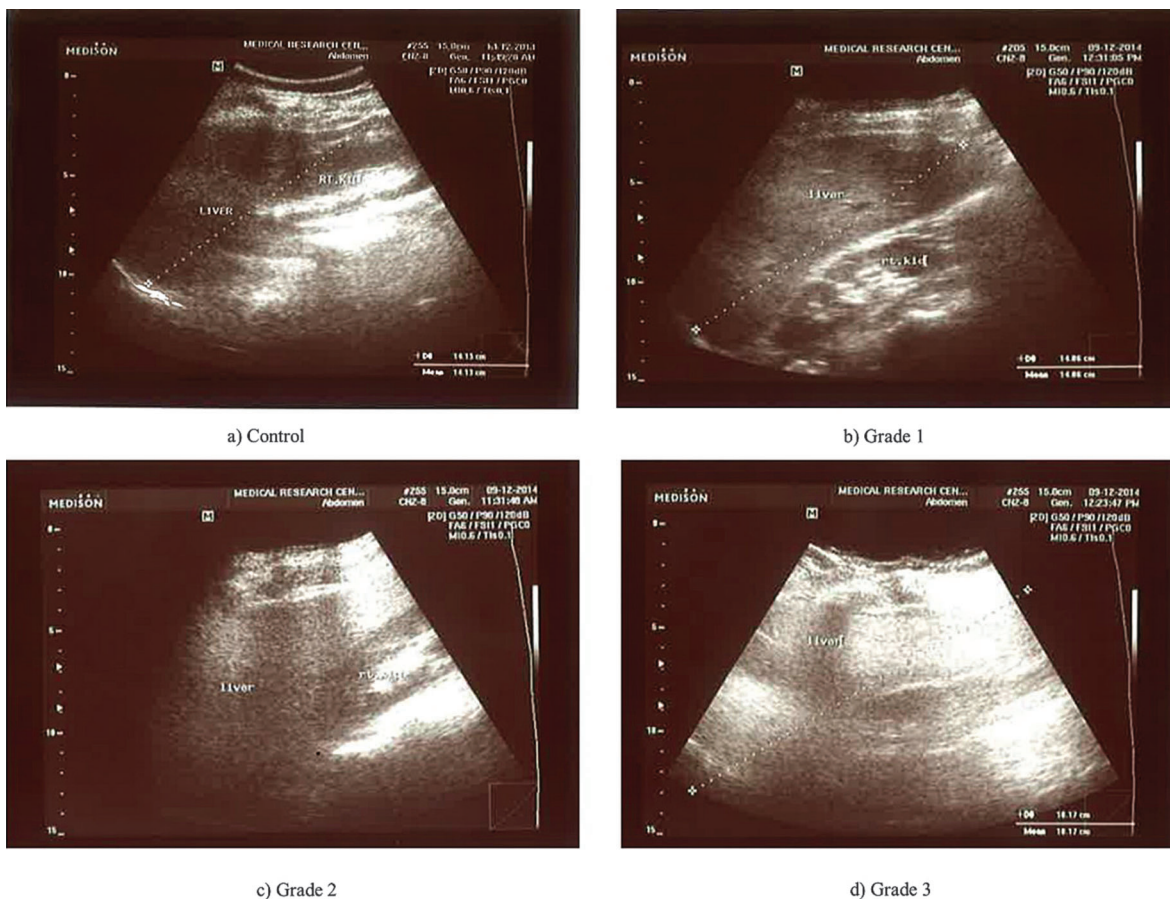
Grades of fatty liver on visual analysis. Ultrasound image shows (a) normal liver echogenicity, (b) grade 1 fatty liver with increased liver echogenicity, (c) grade 2 fatty liver with the echogenic liver obscuring the echogenic walls of the portal venous branches, and (d) grade 3 fatty liver in which the diaphragmatic outline is obscured.
